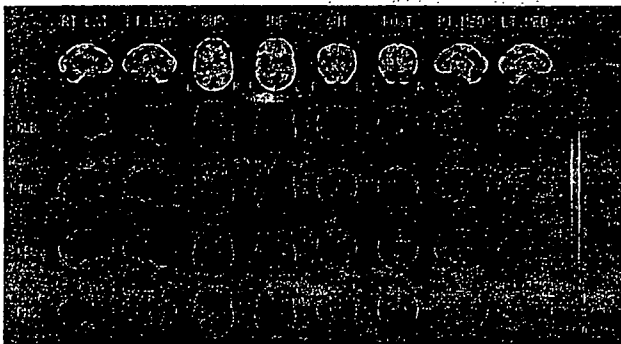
Z-score images of three-dimensional stereotactic surface projections (3D-SSP) are shown from a representative Alzheimer’s disease (AD) patient. These images demonstrate a decrease in the glucose metabolism and regional cerebral blood flow (rCBF). Upper panel: 2-[<sup>18</sup>F]-Fluoro-2-deoxy-D-glucose positron emission tomography (FDG-PET). Lower panel: N-Isopropyl-p-<sup>123</sup>I iodoamphetamine single photon emission computed tomography (IMP-SPECT). The extracted data sets are displayed on eight different angles, including the lateral (RT LAT, LT LAT), medial (RT MED, LT MED), superior (SUP), inferior (INF), anterior (ANT), and posterior (POST) views. With the 3D-SSP programs in NEUROSTAT, the pixel values are normalized to the whole brain (GLB), thalamus (THL), cerebellum (CBL), and pons (PNS)
